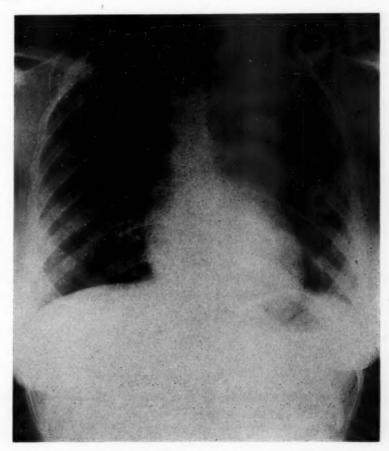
Roentgenogram of the chest. Note cardiac enlargement and notching of ribs.
